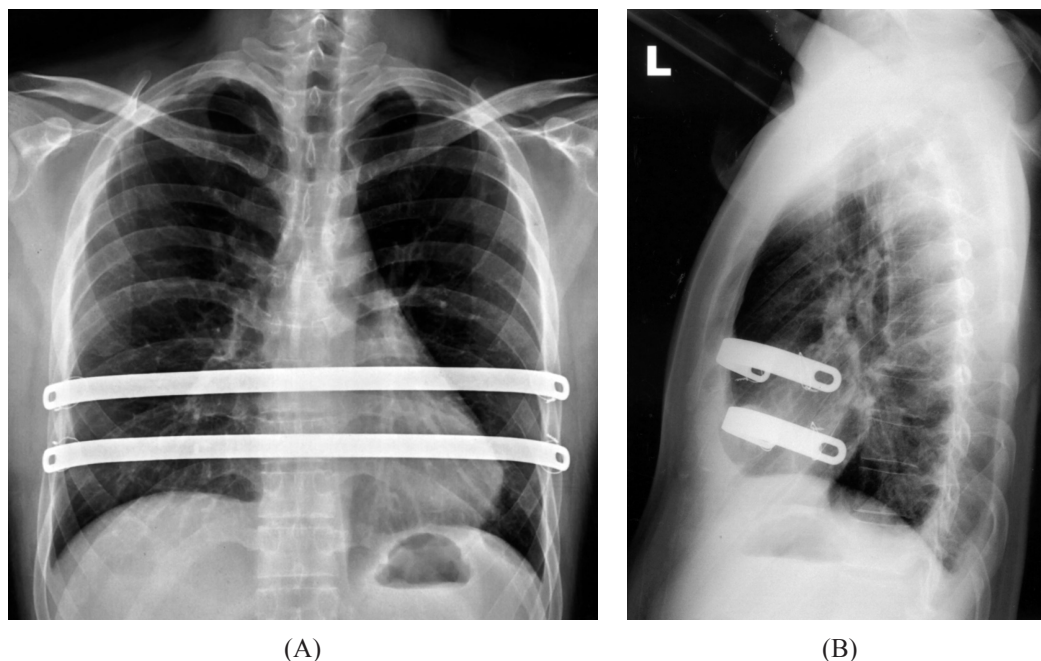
Posteroanterior view (A) and lateral view (B) chest radiographs on the 2nd day after the Nuss procedure, showing normal cardiac size and the accurate placement of pectus bars.
